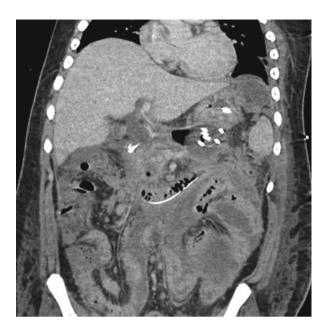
CT scan, the pseudocyst in retrogastric position to subhepatic area
